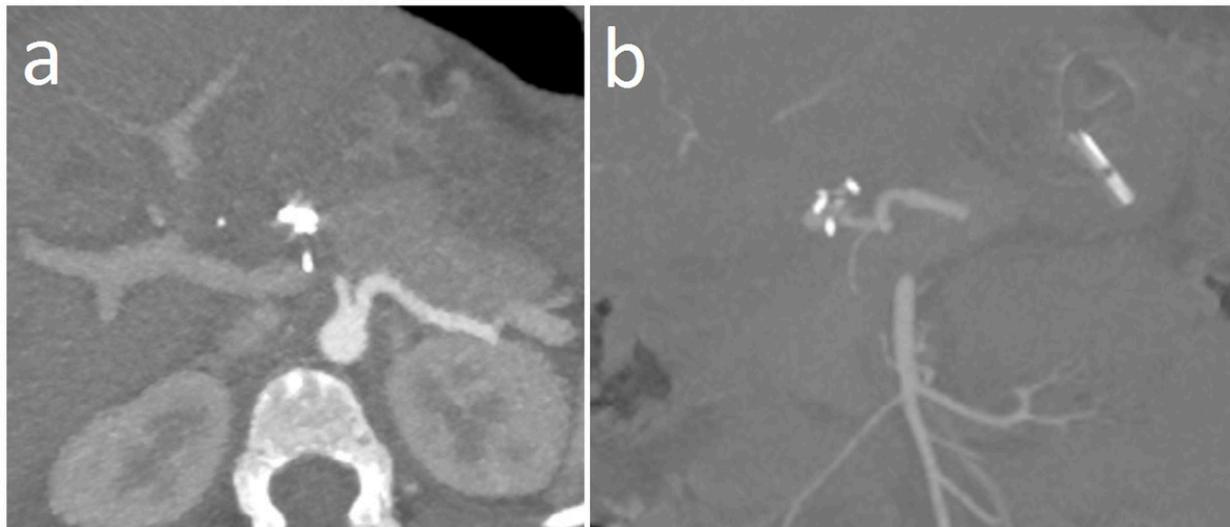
Arterial complications: Thromboses and Pseudoaneurysm. a) Axial CT with Maximum Intensity Projection that shows an independent origin of the liver artery with proximal amputation caused by a thrombosis; b) Coronal CT with maximum intensity projection showing a pseudoaneurysm (arrow) of the liver artery at the site of anastomosis.
